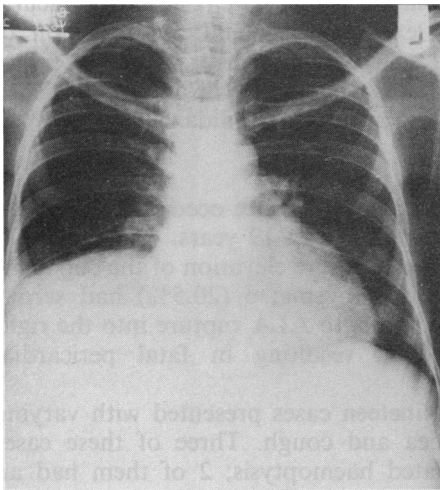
Posteroanterior chest X-ray showing marked elevation of right hemidiaphragm
